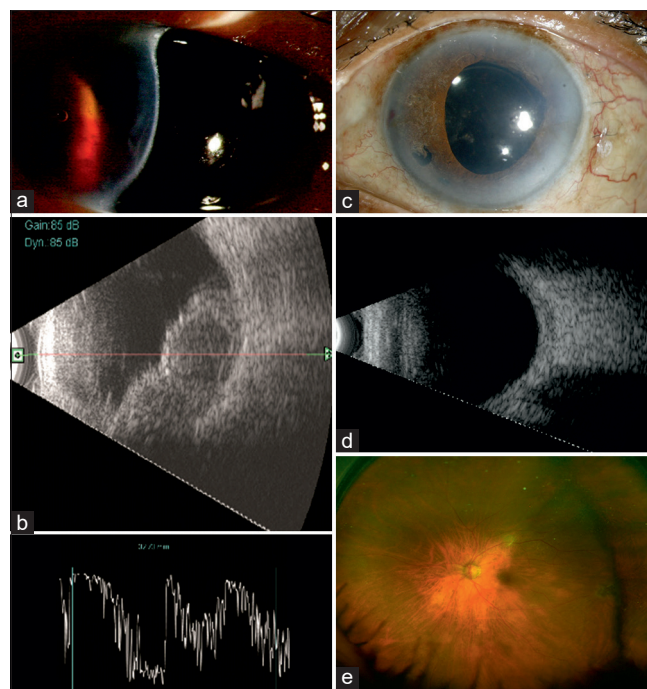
Shows (a) Pre-operative corneal edema, hyphema, and aphakia in Case VI, (b) Pre-operative B-scan ultrasonography (USG) showed suprachoroidal hemorrhage (SCH) in two quadrants, (c) Stable intraocular lens (IOL) position after silicone oil removal (SOR) and glued IOL implantation, (d) USG after SOR showed completely resolved SCH and (e) Retinal status without any residual suprachoroidal elevation after SOR
